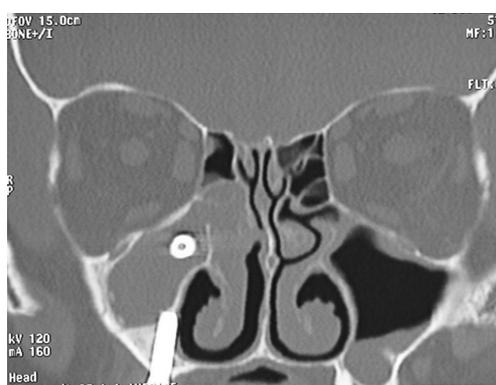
Coronal computed tomography scan clearly revealed the dental implant located in the upper third of the maxillary sinus. Acute maxillary sinusitis and ethmoiditis are evident.
